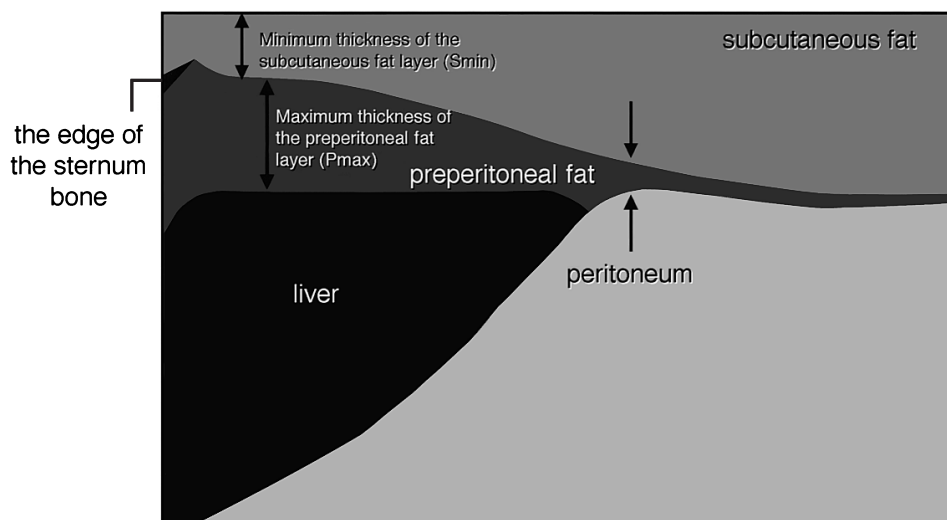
Measurement of thickness of the preperitoneal and subcutaneous fat layer by abdominal ultrasonography. Abdomen is sagittally scanned from the end of sternum to navel by ultrasonography. Maximum thickness of the preperitoneal fat layer (Pmax) and minimum thickness of the subcutaneous fat layer (Smin) are estimated.
